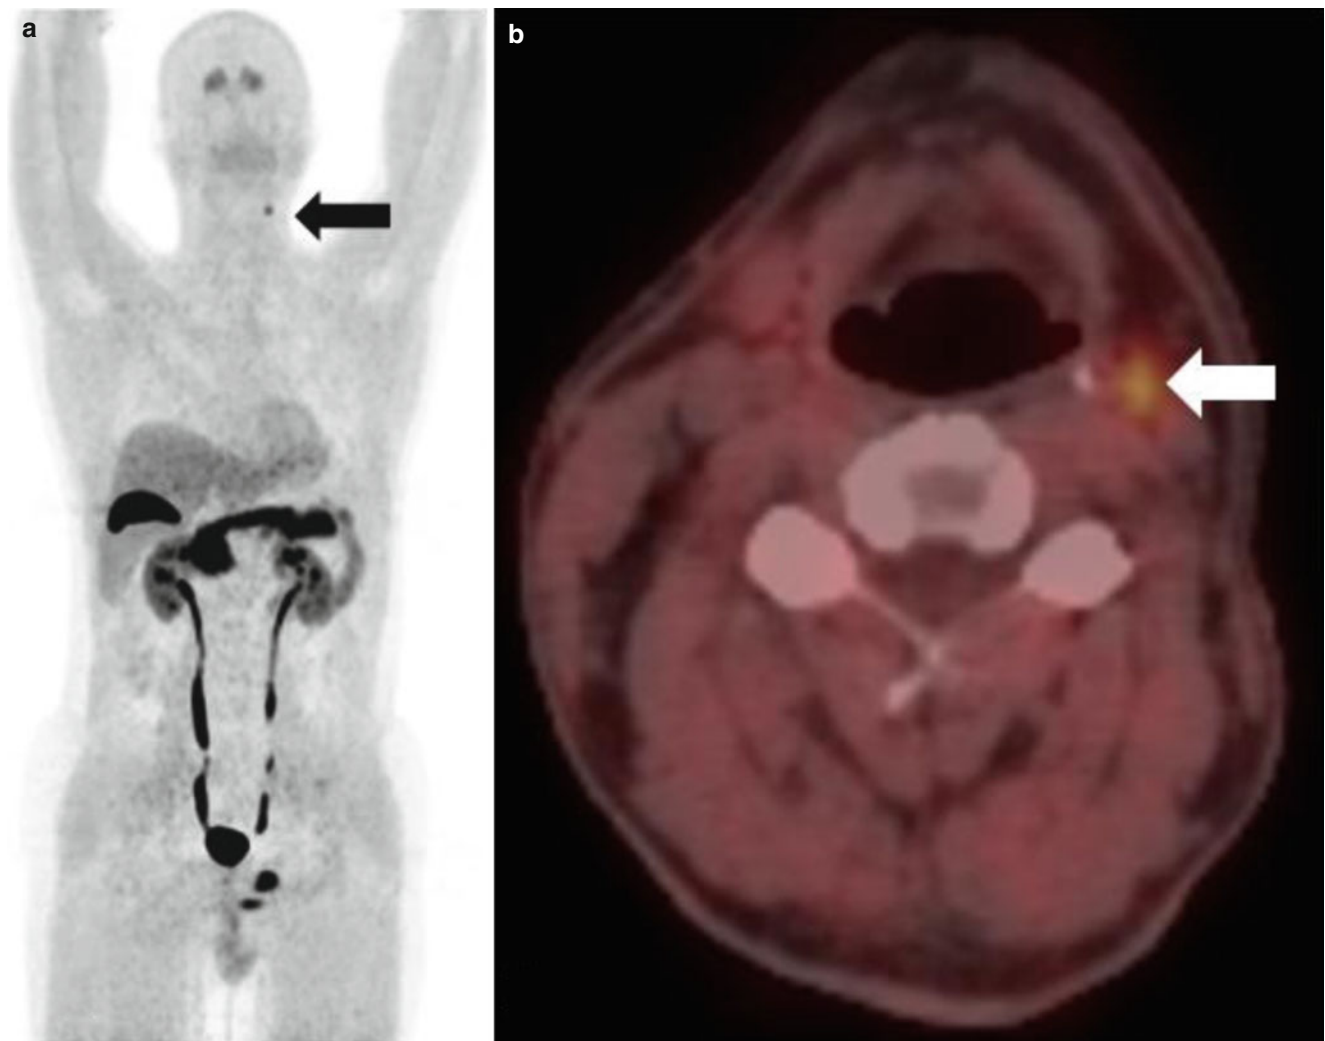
MIP (a) and fused transversal (b) ^{18}F -DOPA PET/CT images in a patient presenting with biochemical recurrence of medullary thyroid carcinoma. The PET images nicely show intense tracer uptake a single subcentimetric metastasis in the left cervical lymph node area III
